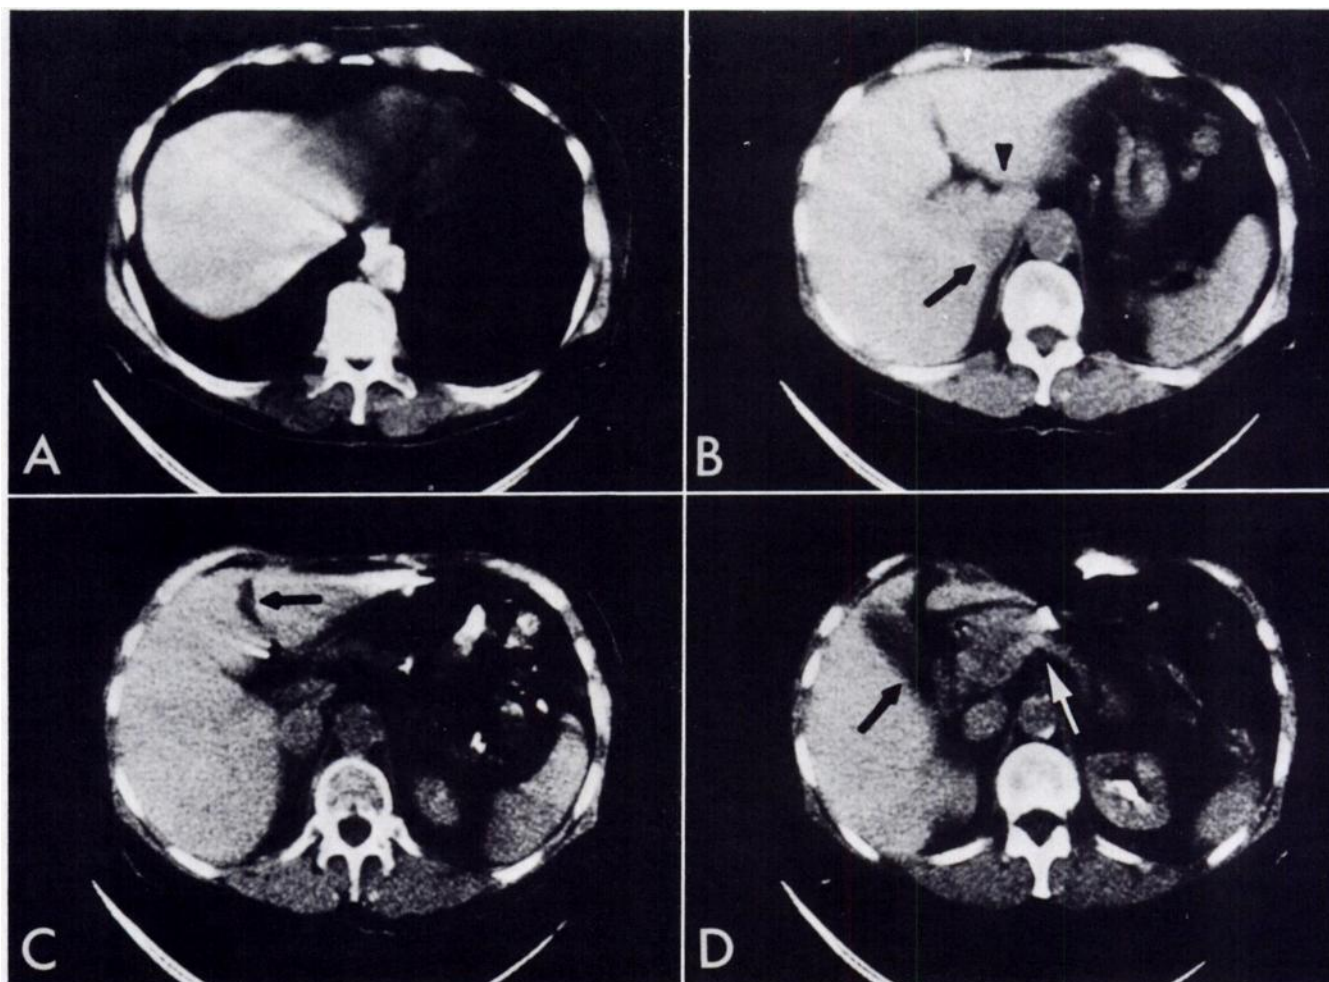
CT scans of normal liver. *A*, Uppermost scan showing dome of right lobe surrounded by lung. Streaklike artifacts caused by motion of heart, seen to left of liver. *B*, Scan at next level showing caudate lobe between fissure for ligamentum venosum (arrowhead) and inferior vena cava (arrow), which is within substance of liver. *C*, Scan at next level showing extrahepatic vena cava, quadrate lobe between fissure for falciform ligament and ligamentum teres (arrow), and gallbladder fossa, also seen at still lower level (*D*). *D*, Scan at lowest level showing gallbladder (black arrow) as low density structure on visceral surface of liver. Pancreas (white arrow), left kidney, and upper pole of right kidney also seen. Left renal collecting system opacified with previously administered contrast material.
